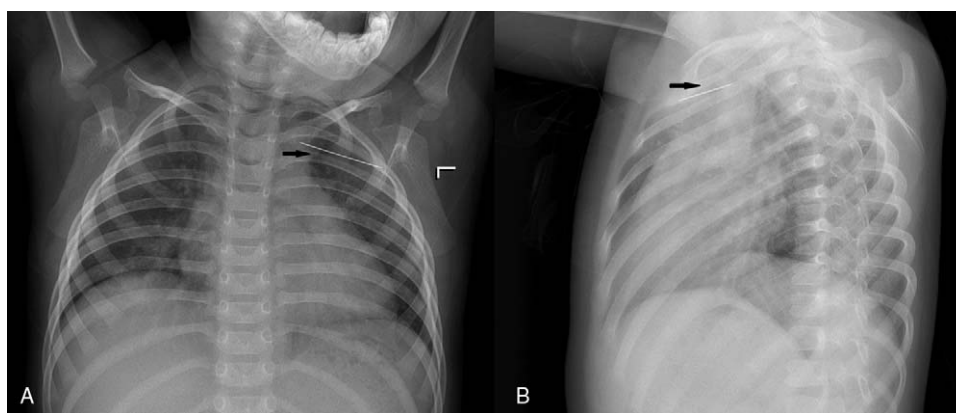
Chest X-ray images in coronal and sagittal views: case 2. Black arrows indicate the needle.
